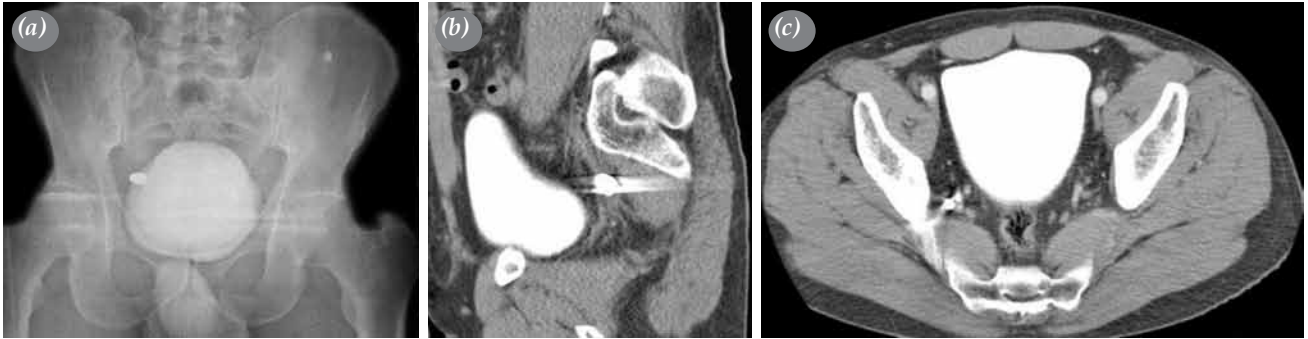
(a) Bullet-like opacity in pelvic radiography, (b, c) coronal and sagittal section of pelvic computed tomography demonstrating bullet close to internal iliac vascular bundle.
